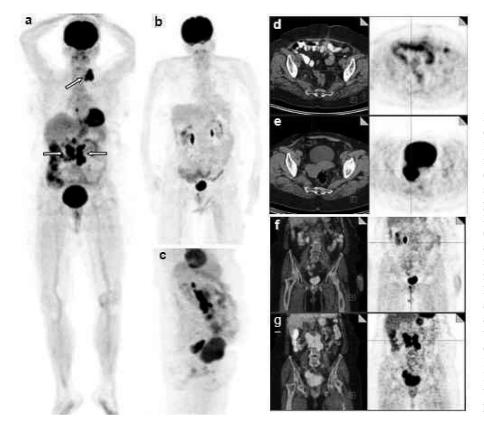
Flourine-18 fluoro-deoxyglucose positron emission (F-18 FDG PET/CT) imaging before treatment, maximal intensity projection (MIP) images show hypermetabolic supraclavicular (SUV max = 23.08), paracaval, para-aortic (SUV max = 28.78) (a) and right adnexial mass (SUV max = 28.87); (c) (arrows), (e)axial images of pelvic computed tomography and PET (from left to right, respectively) showing adnexial hypermetabolic mass; (g) coronal images of abdominal fusion PET/CT and PET (from left to right, respectively) showing para-aortic, paracaval hypermetabolic conglomerated lymph nodes. After treatment, PET/CT images, showing no residual tumour; (b) MIP image; (d) axial pelvis; (e) coronal abdomen images.
